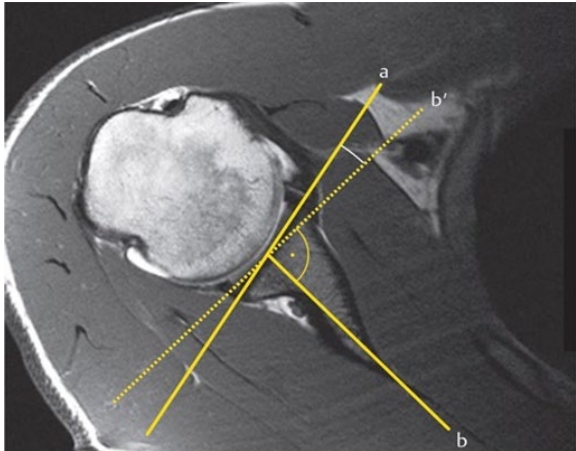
An axial shoulder MRI image showing the measurement of glenoid version (Hohmann & Tetsworth, 2015).
